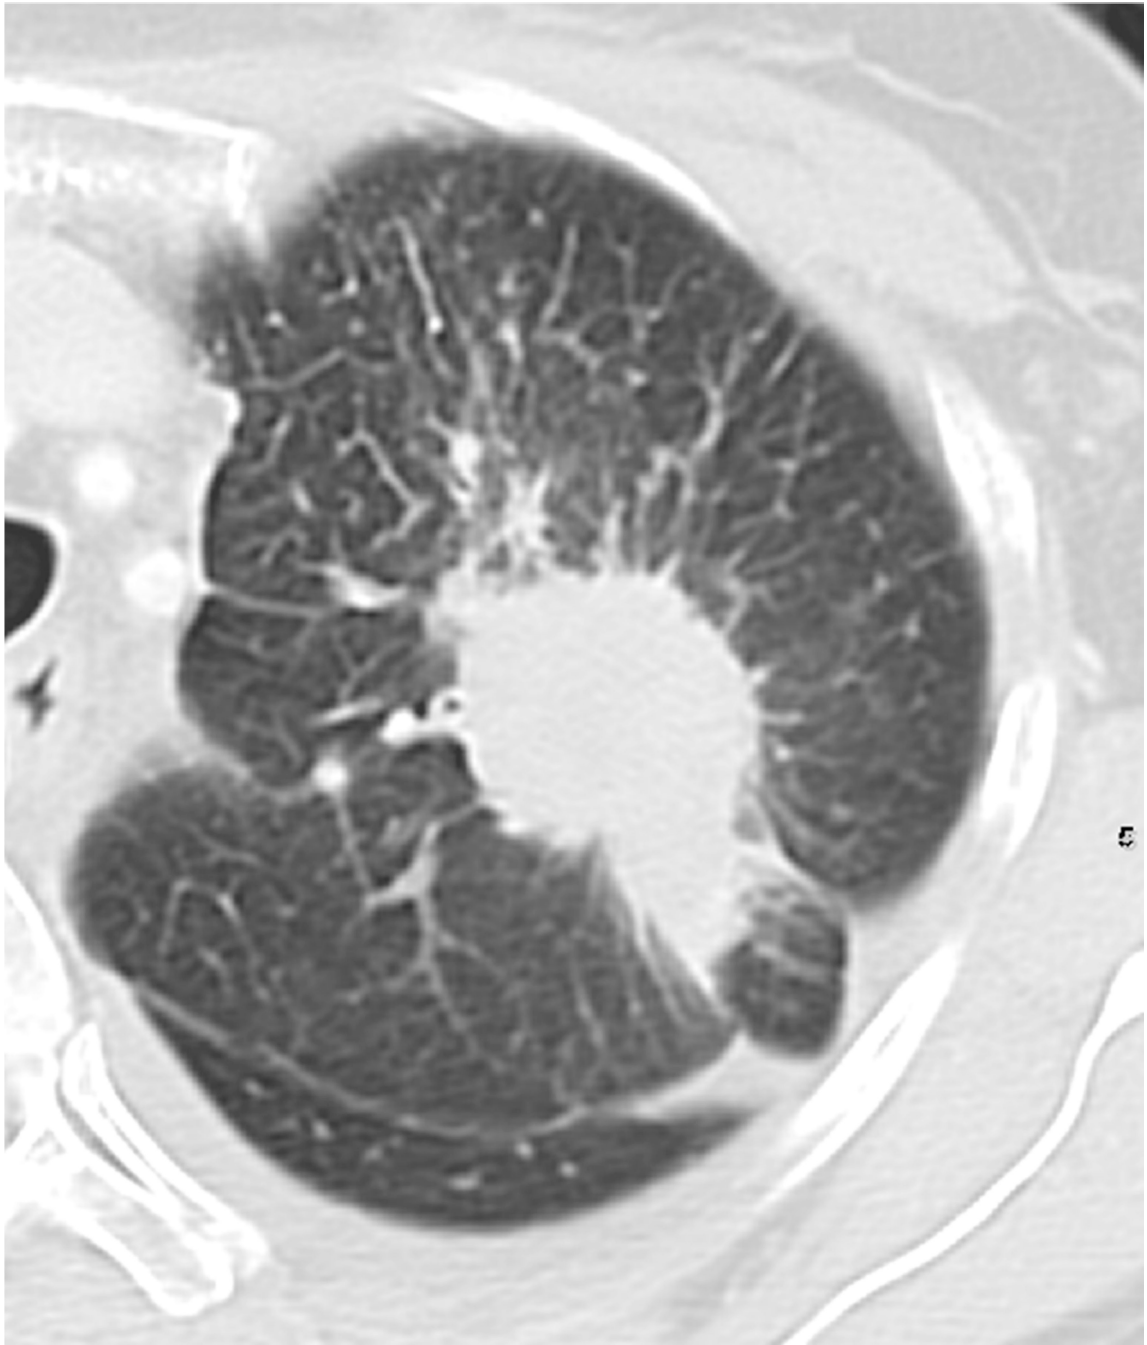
Coned down view of an axial CT. 63 year old female with a left upper lobe adenocarcinoma demonstrating peripheral location, solid in nature and spiculated margins. Genomic profiling revealed a *ROS1* fusion.
